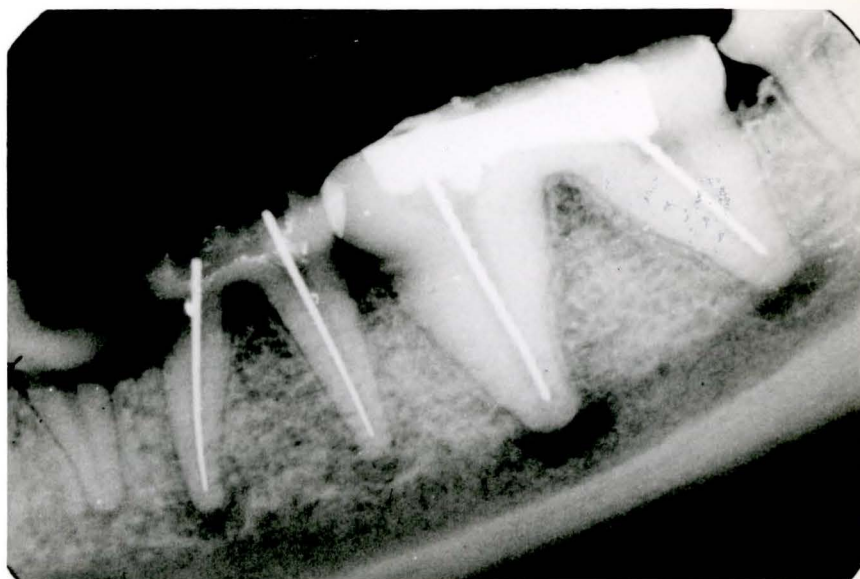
Radiograph (*in vivo*) indicating the abrupt ending of the main root canals. The files placed in each canal hit a "dead stop" at this location in all cases.
